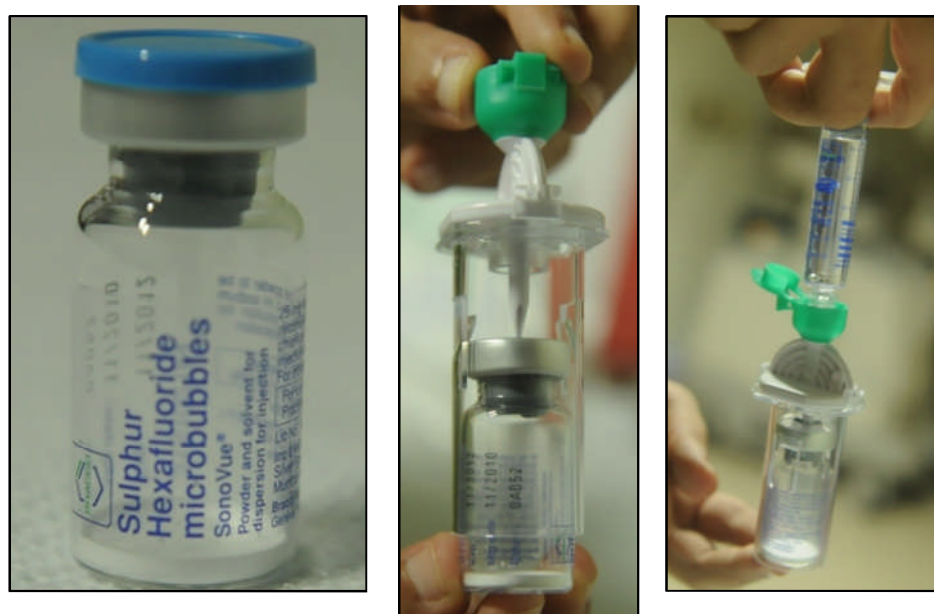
Ultrasound contrast medium SonoVue, Bracco
